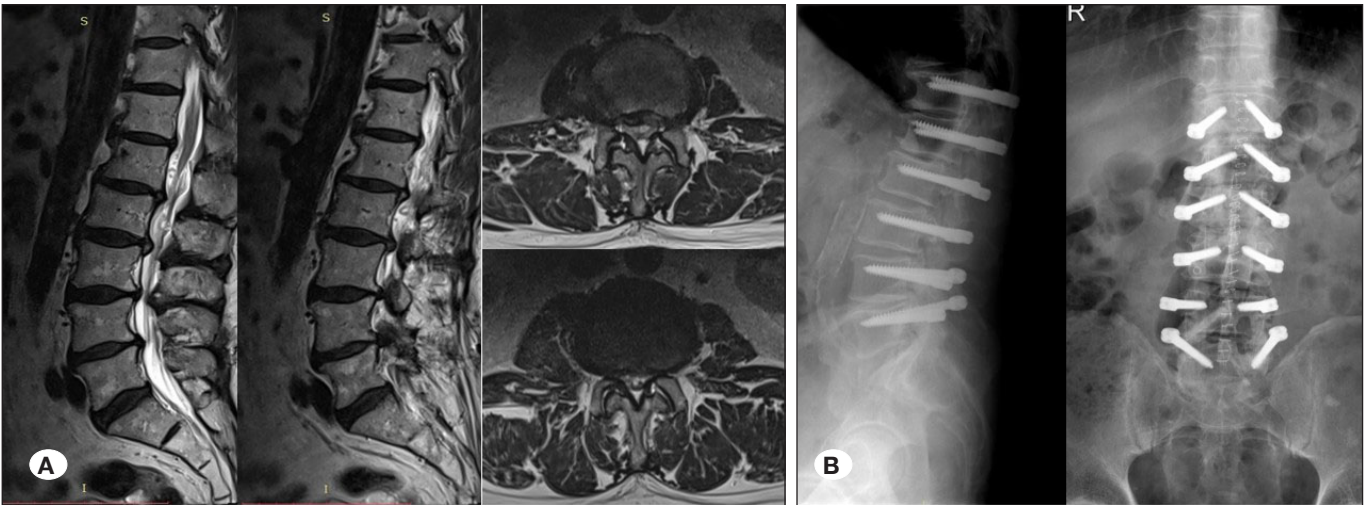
A 70-year-old male patient presented with severe low back pain A) L2-3 and L3-4 narrow canal and diffuse degenerative disc disease are seen on MRI B) dynamic stabilization was performed using the multilevel Dynesys system.
